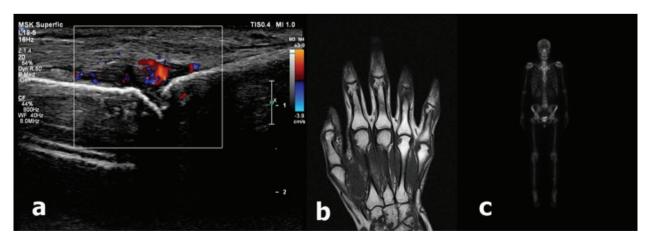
Imaging techniques: (a) ultrasound + power Doppler; (b) magnetic resonance imaging; (c) scintigraphy.
